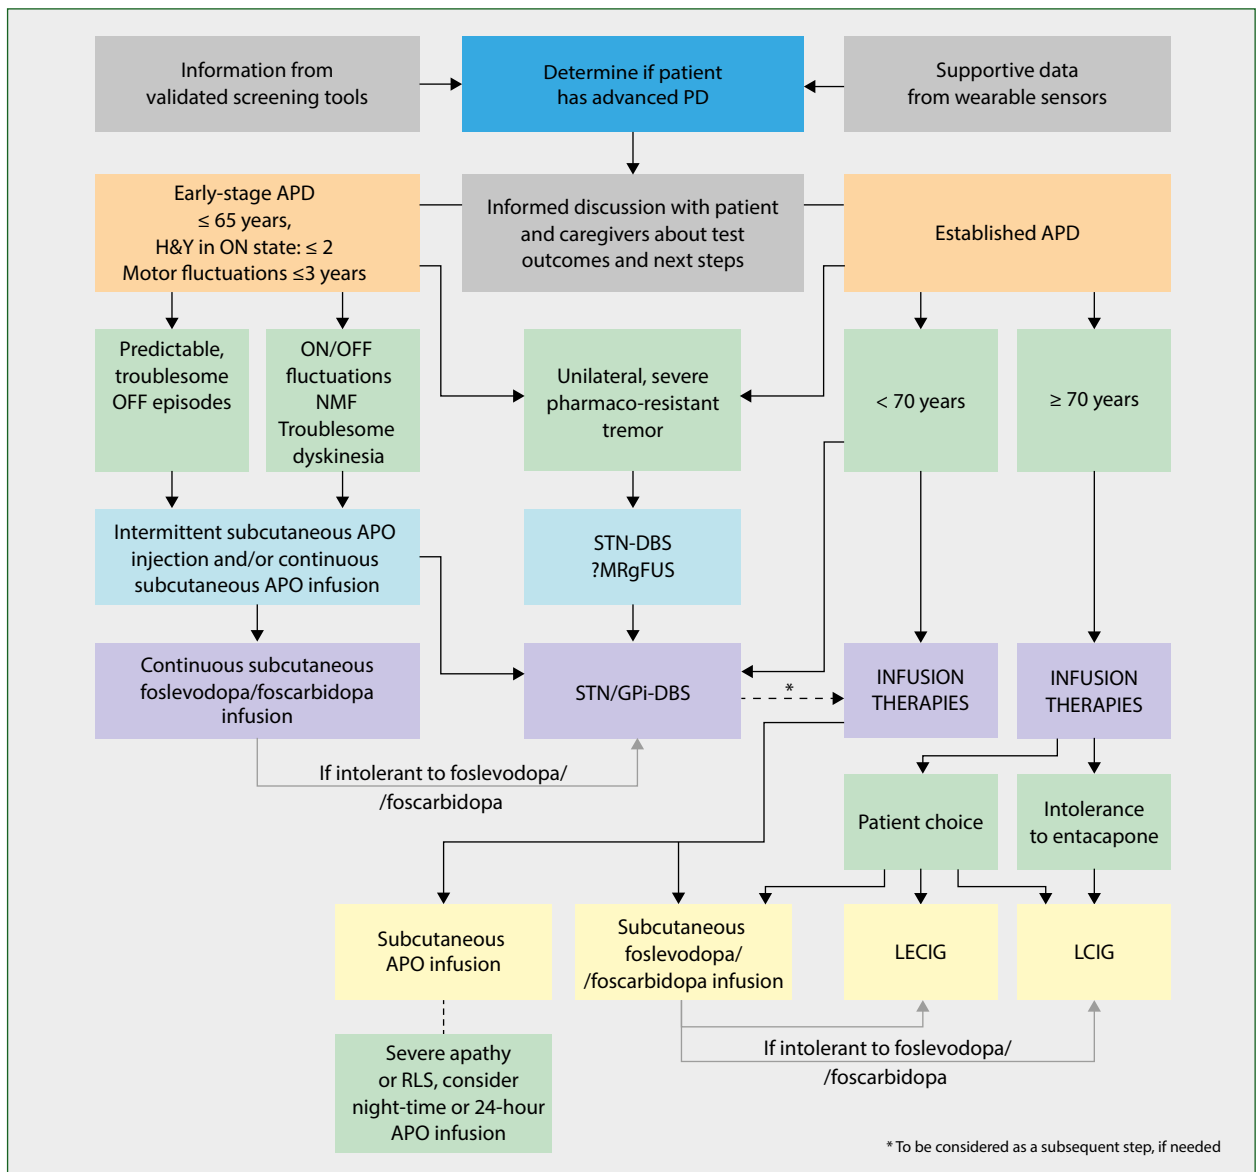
Suggested algorithm for clinical use of available device-aided therapies in Poland for advanced PD. Modified from Popławska-Domaszewicz et al. [13]. APD – advanced PD; APO – apomorphine; DBS – deep brain stimulation; GPi – globus pallidus internus; H&Y – Hoehn & Yahr; NMF – non-motor fluctuations; MRgFUS – MRI-guided focused ultrasound; PD – Parkinson’s Disease; PKG – Parkinson’s KinetiGraph; RLS – restless legs syndrome; STN – subthalamic nucleus; LECIG – levodopa-entacapone-carbidopa intestinal gel; LCIG – levodopa-carbidopa intestinal gel; indicates possible consideration of technique if locally available
